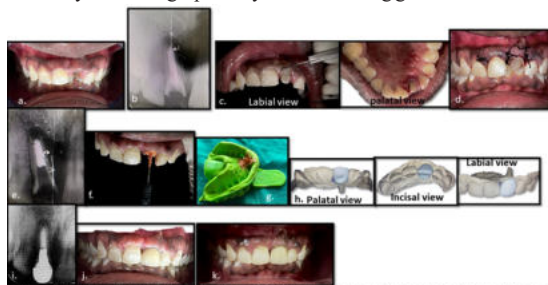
a) Pre-op Clinical Picture wrt #21 b) Pre Op Radiograph c) Internal bevel incision wrt #21 on the labial aspect and palatal aspect d) Suture placement e) Confirmatory Radiograph after post space preparation of 10mm f) Light body impression with number 80 k-file after even spreading of the material within the canal with lentulo spiral g) Final Impression made using elastomeric impression material h) Virtually designed Richmond Crown using Exocad Software i) Radiographic Evaluation j) Clinical Evaluation and luting k) 1 month follow up.
